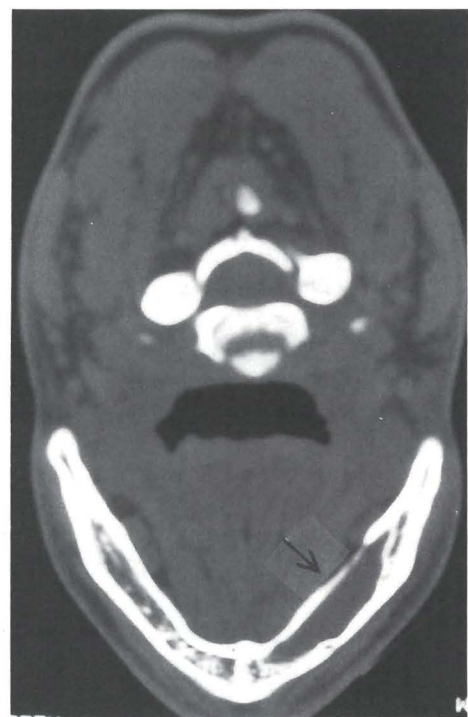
Another CT cut showing internal permeation of the lingual plate of bone.
